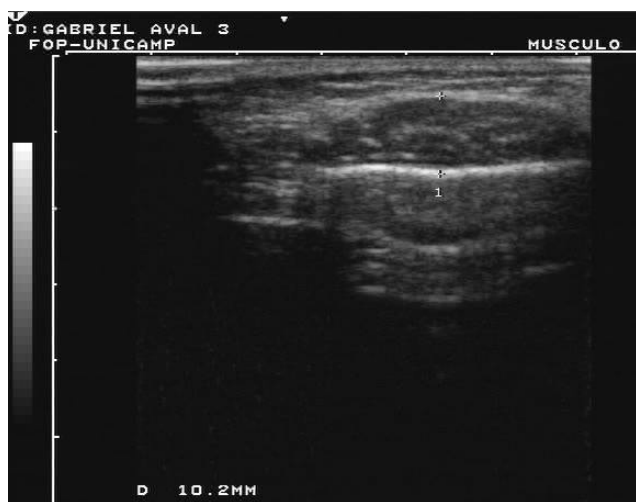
Caso clínico 2: imagem ultrasonográfica do músculo masseter (lado direito) em repouso (fase 3).
